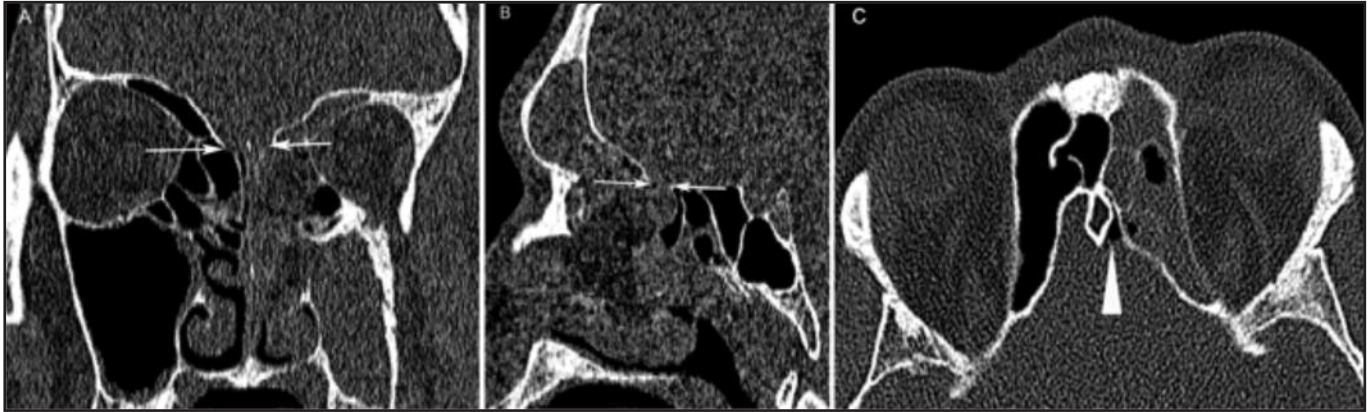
CT base of skull of Case one demonstrating a left cribriform plate defect, near the fovea ethmoidalis (white arrows) with fluid opacification of the left sided paranasal sinuses. There is air in the anterior cranial fossa representing pneumocranium (arrowhead in c) which indicates communication between the air-filled paranasal sinuses and intracranial cavity.
